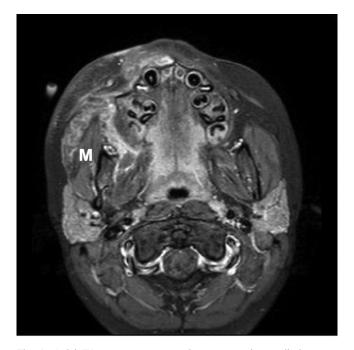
Axial T1 postcontrast magnetic resonance image discloses an irregular, multilobulated enhancing mass in the right masticator space, both superficial and deep to the anterior aspect of the masseter muscle (M). Anterior extension of the mass is noted abutting the right maxillary alveolar process, whereas posterior extension abuts the parotid gland.
